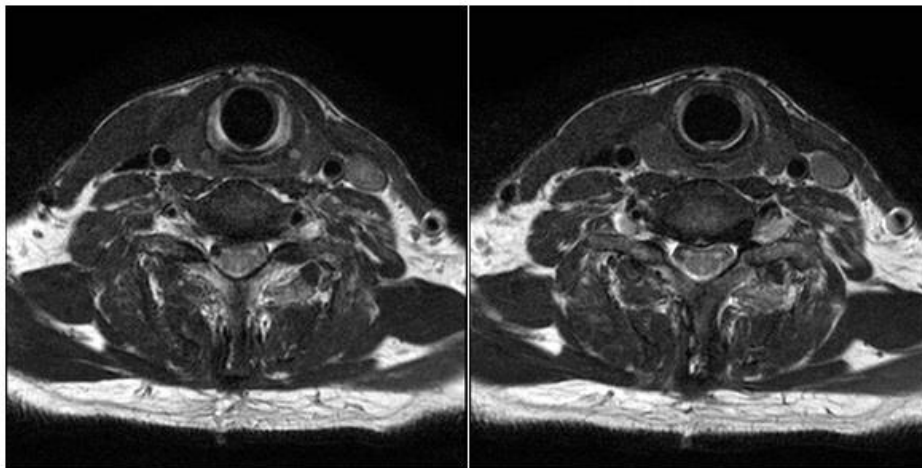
The MRI shows atrophy of left sternocleidomastoid muscle.
